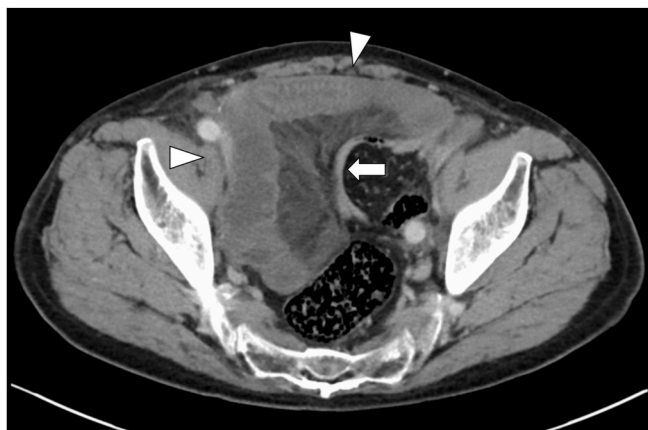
Computed tomography of the pelvis showed dilatation of the small bowel (white arrowhead) and decompressed distal bowel (white arrow).
